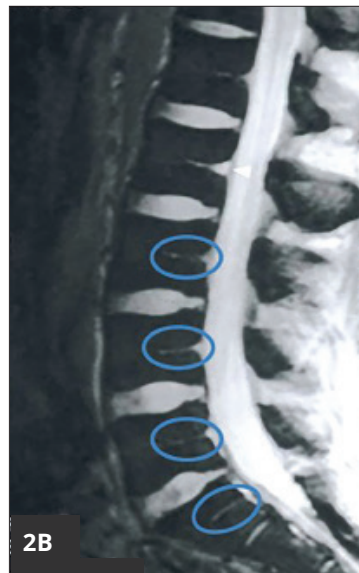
Anatomy of basivertebral nerve (BVN). Note the bifurcation of the nerve at the terminus. The terminus is located in the posterior one-third of the vertebral body and is the target for ablation proximal to the sprouting of nerves that supply the endplates. Figure 2B. Lateral MRI, view of basivertebral nerve foramen (circles). Figure 2C. Introducer trocar shown being advanced through the pedicle until it breaches the posterior vertebral wall. Figure 2D. Replacement of the introducer trocar shown being replaced with a smaller curved cannula to facilitate a path to the basivertebral nerve ablation.
